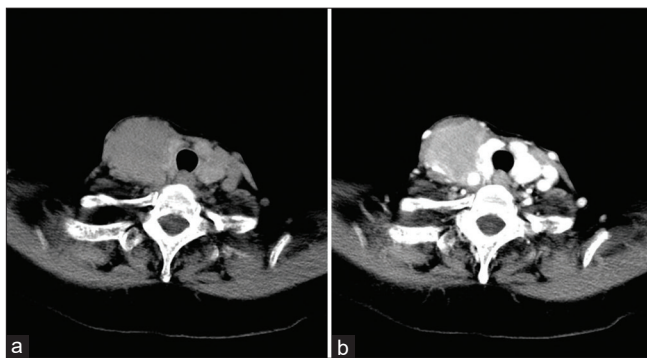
(a) Noncontrast enhanced computed tomography shows a hypodense nodule (size: $4.1 \text{ cm} \times 3.6 \text{ cm} \times 4.5 \text{ cm}$) in the right lobe of thyroid gland. (b) This nodule shows minimal homogeneous enhancement on contrast enhanced computed tomography imaging. The trachea, vessels and soft tissues in the right neck are under pressure and displaced toward the left side
